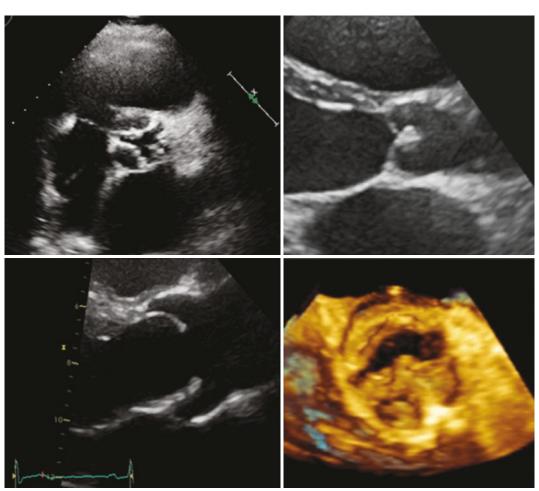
Parasternal short axis of a degenerative aortic valve with moderate stenosis (top left).Parasternal long axis view of a rheumatic aortic valve with characteristic thickening at the leaflet tips (top right). Parasternal long
